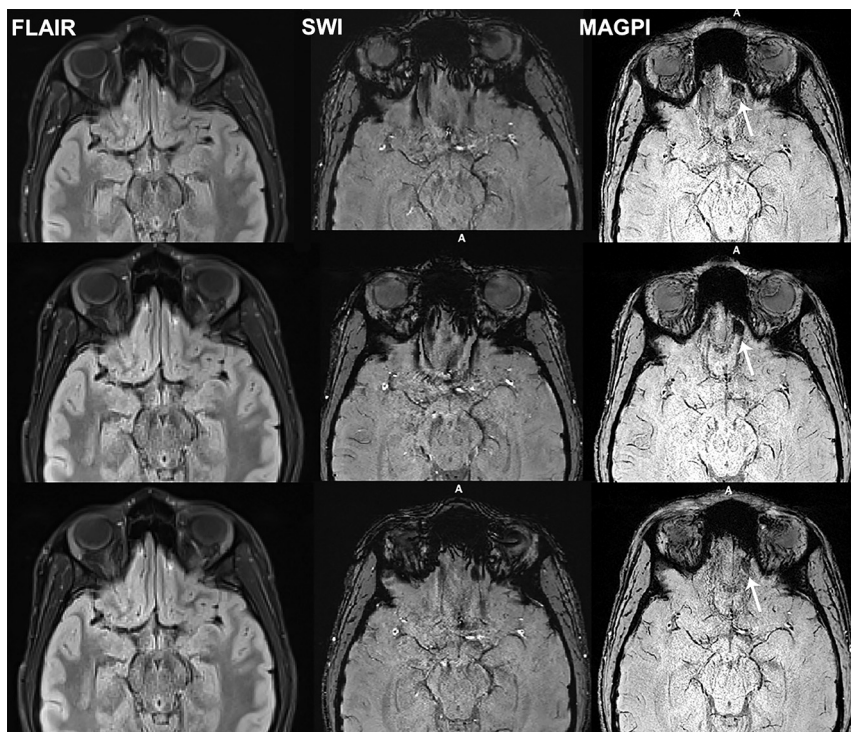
A football player who had helmet-to-helmet frontal trauma (participant 7). The initial postconcussion symptom scale was 37. MR images shown are FLAIR, SWI, and MAGPI-SWI obtained at 2 days (*upper row*), 2 weeks (*middle row*), and 6 weeks (*lower row*) after head trauma. There is a microbleed in the left inferior frontal lobe best seen on MAGPI-SWI (*arrows*). No definitive contusion is visible on FLAIR images. The susceptibility signal on visit 3 (6 weeks after trauma) has slightly decreased in size and intensity. Please note that this microbleed was exaggerated on the traditional SWI due to skull base-related susceptibility artifacts and thus less confidently noticed. The Post-Concussion Symptom Scale score was 0 at 6-week follow-up.
